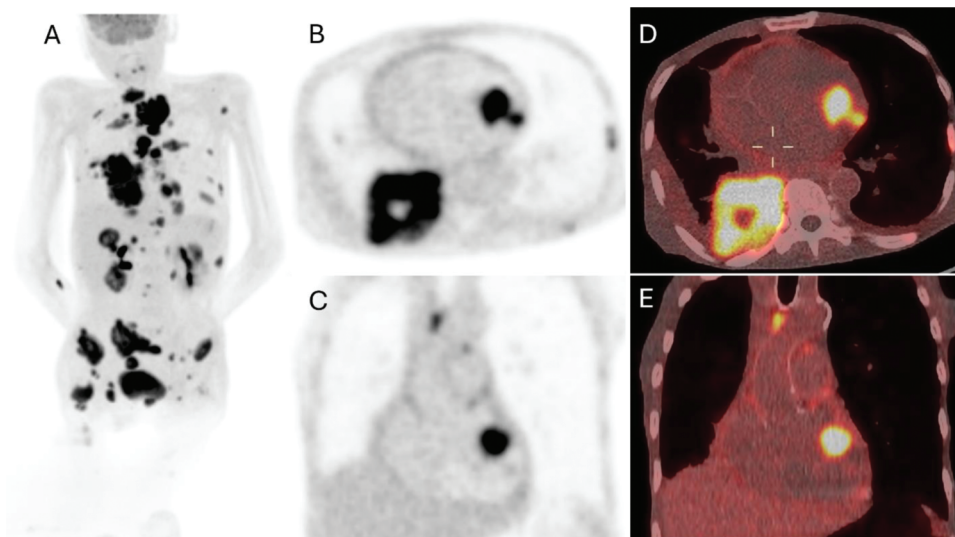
Patient 3 Panel A: Whole-body PET maximum intensity projection (MIP) image demonstrating FDG-avid right lung malignancy with metastatic involvement of the liver, skeletal system, adrenal glands, lymph nodes, and heart. Panels B and C: PET axial and coronal images highlighting myocardial metastases. Panels D and E: Fused PET/CT axial and coronal images confirming myocardial metastases at sites corresponding to lesions identified on echocardiography.
